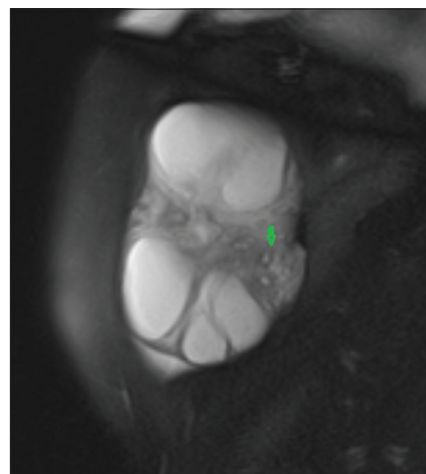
Fat-suppressed sagittal T2-weighted magnetic resonance imaging showing increased ovarian size, peripherally arranged cysts, microcysts harboring the peripheral hypointense hemosiderin ring, marked stromal edema, and free fluid in the inferior part of the ovary
